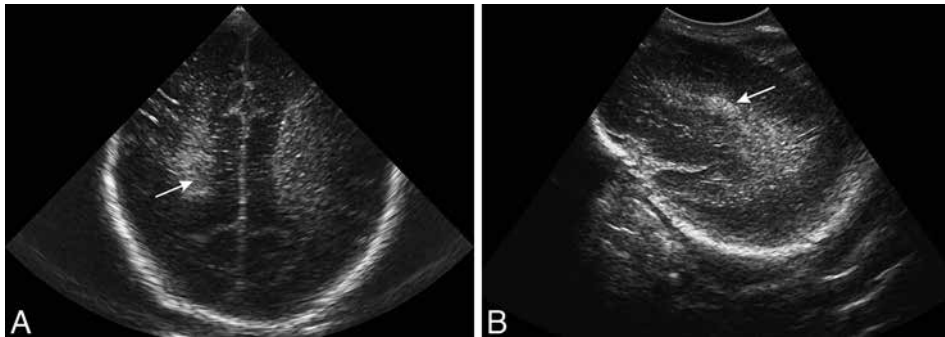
Coronal (A) and parasagittal (B) ultrasound scans in preterm infant (gestational age 32 wk), showing inhomogeneously increased echogenicity (arrows) in the parietal white matter on the right side.
